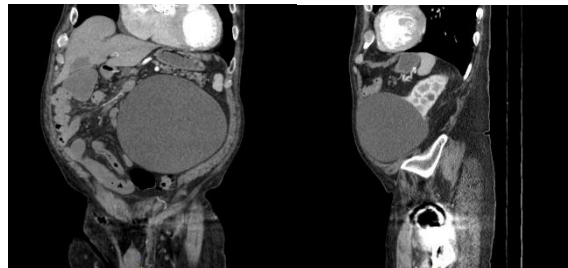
Coronal (left) and Sagitta (right) views of abdomen on CT.
